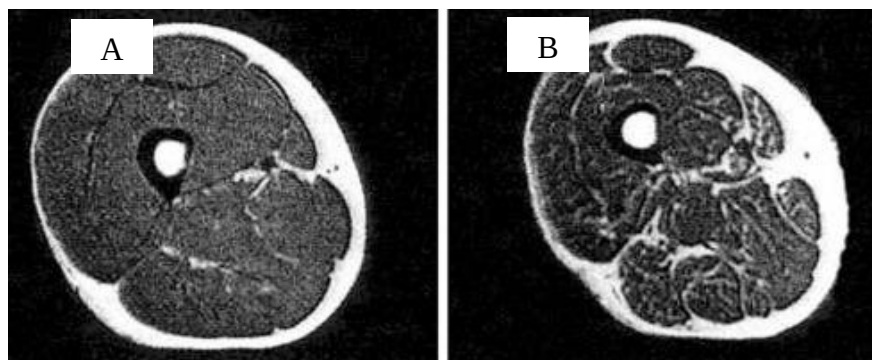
A: MRI of healthy thigh muscle and B: MRI of sarcopenic thigh muscle
